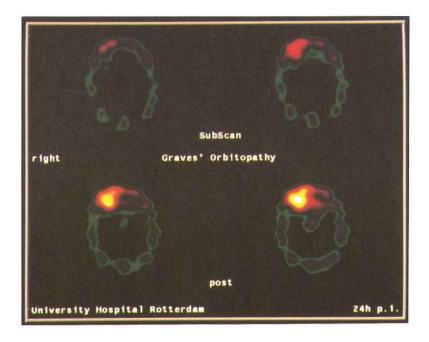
Uptake of radioactivity in a patient with unilateral ophthalmic Graves' disease (SPECT, 24 h post injection)
